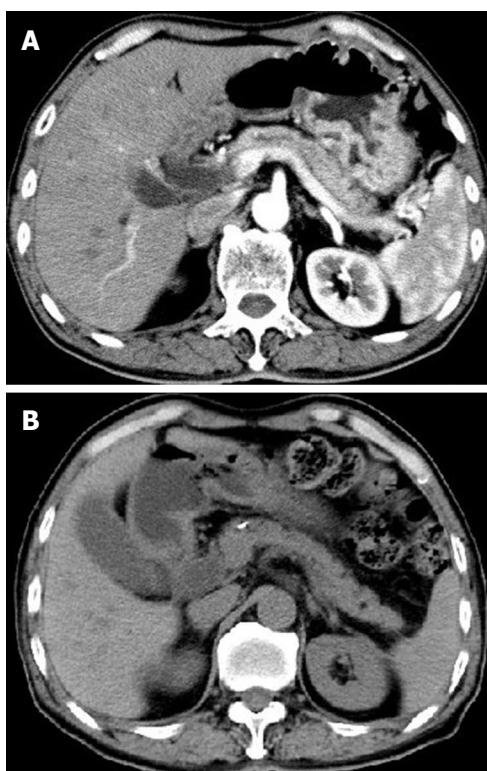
Computed tomography in June and November 2012 revealing the normalized pancreas after steroid treatment.
